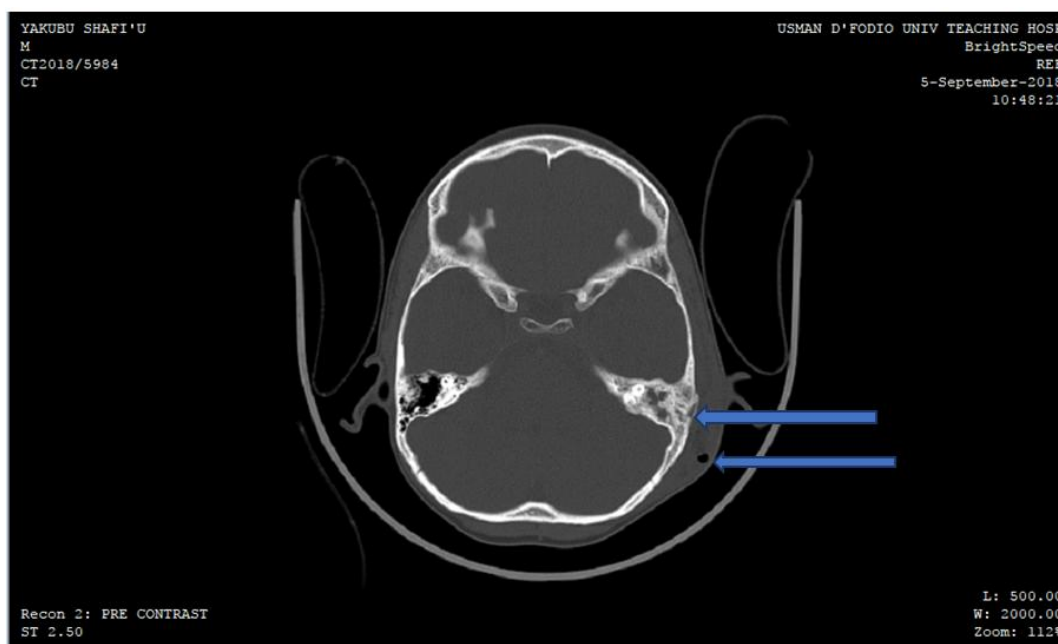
CT scan of a 10-year old boy showing opacification of the left mastoid air cells with associated swelling of the overlying soft tissue with the focus of lucency and bony erosion shown by blue arrows
